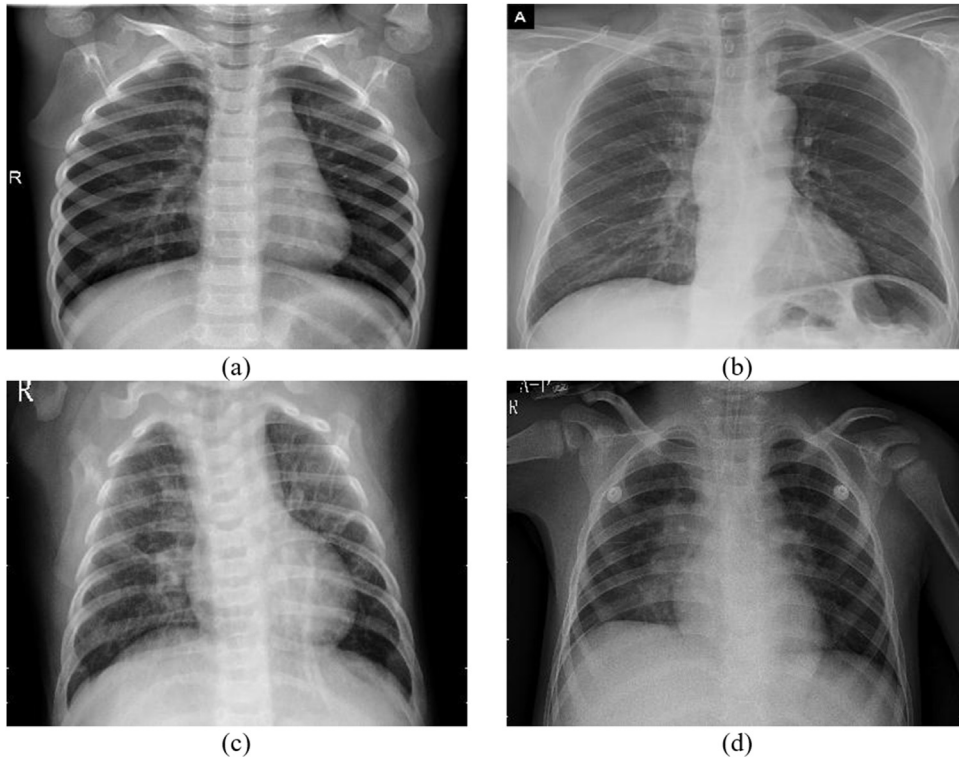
Examples of chest X-ray images from Ref. [30] of subjects diagnosed with (A) normal, (B) COVID-19, (C) viral pneumonia, and (D) bacterial pneumonia.
